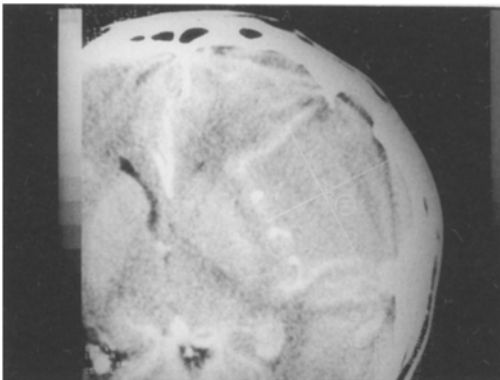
CT scan after contrast enhancement showing an intracystic hemorrhage of the arachnoid cyst in the sylvian area without subdural hematoma.
